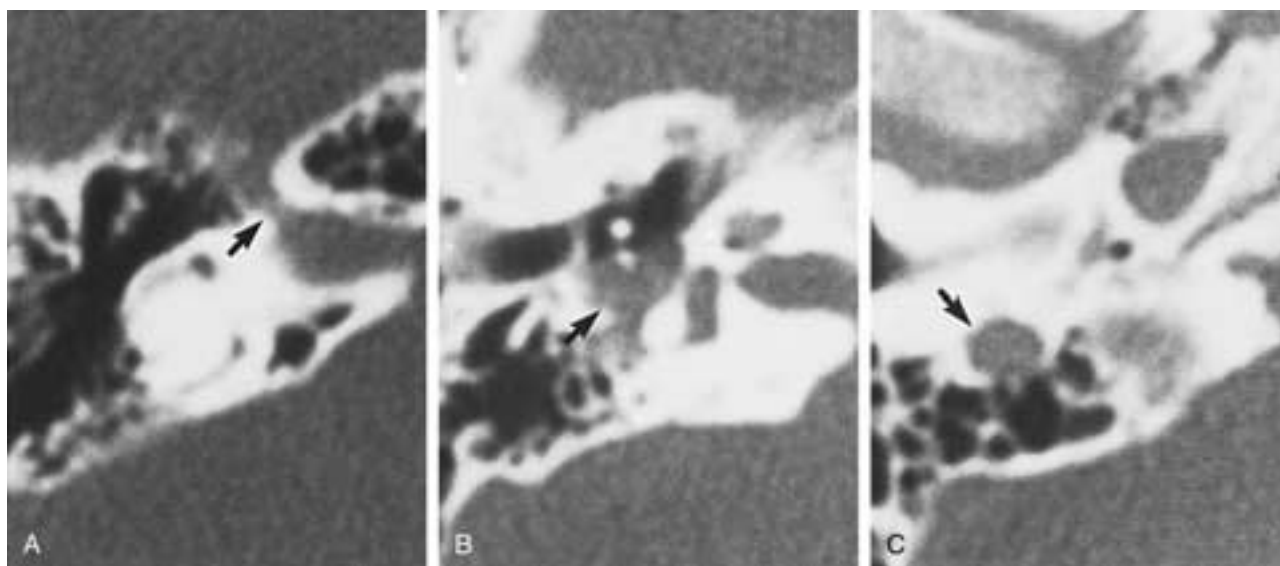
FNC facial schwannoma. A to C, Axial CT. To varying degrees, the tumor has expanded along the entire length of the FNC (*arrows*).
